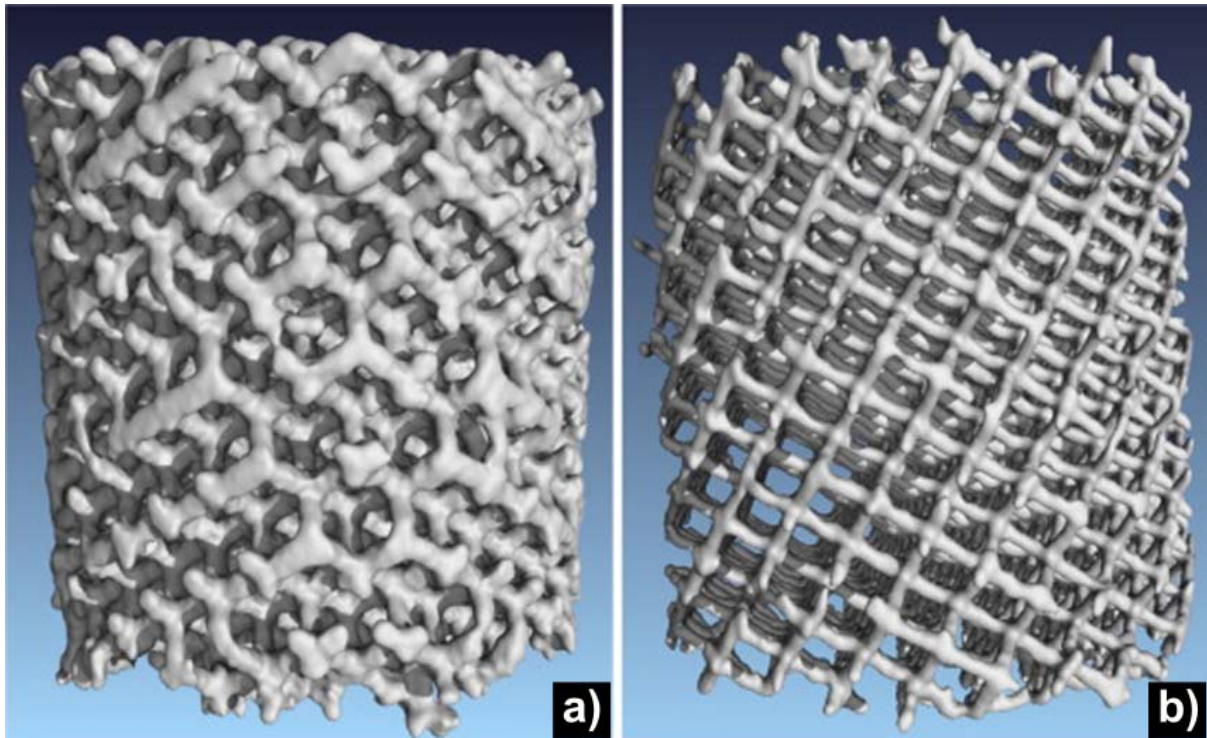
Reconstructions of micro X-ray computed tomography scans of a Ti-6Al-7Nb lattice structure a) before and b) after chemical etching with aqueous 6 vol% HF and 14 vol% HNO₃ for 600 seconds. Note the visible decrease in volume. ²⁴⁹
